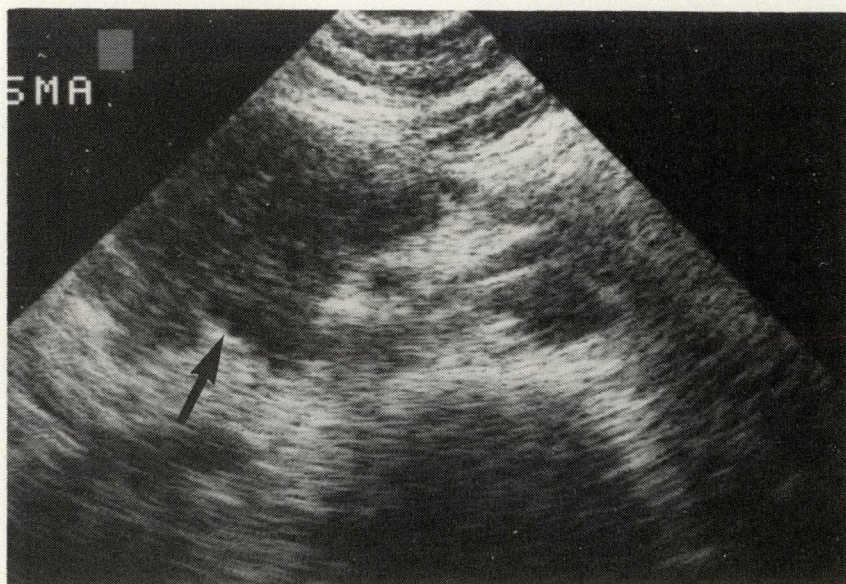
Transverse ultasonogram at level of pancreatic head. Tumour is hypoechoic and encases superior mesenteric vein (arrow).
